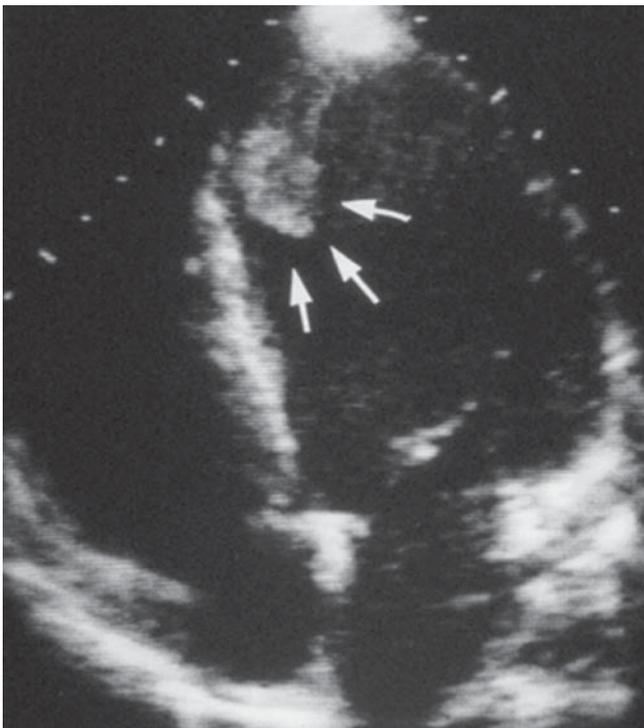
Apical 4-chamber view from a patient with dilated cardiomyopathy. Note the presence of an apical thrombus (arrows). The patient was not receiving anticoagulation
